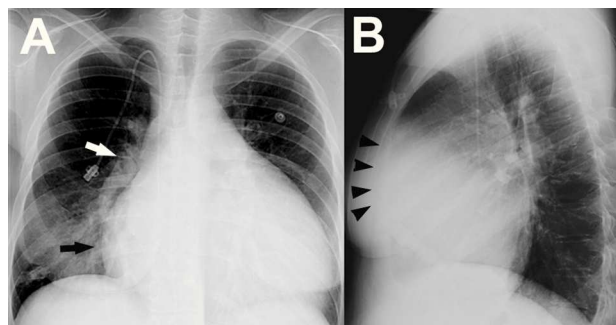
A: postero-anterior chest roentgenogram in a patient with idiopathic pulmonary hypertension showing marked cardiomegaly, right atrial enlargement (black arrow), dilated central pulmonary arteries (right pulmonary artery, white arrow) and diffuse reduction in peripheral vascularity. An intravascular catheter for the infusion of medication is also seen. B: lateral chest x-ray in the same patient demonstrating enlarged right ventricle (black arrowheads).
